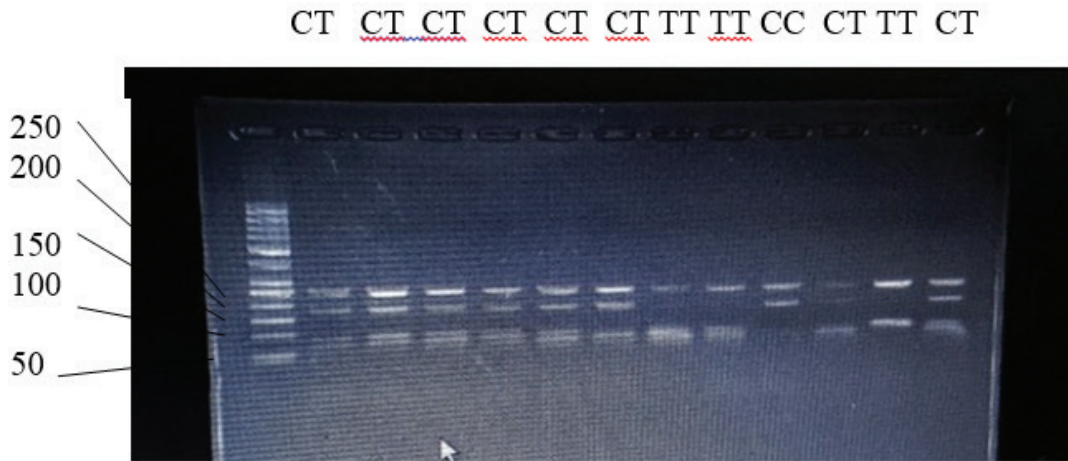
Restriction digestion of PCR products demonstrating the patterns of different genotypes of MYH9 on 2% agarose, 100V; bands of 243+178 bp (CC), 243+92+86 bp (TT) and 243+ 178+92+ 86 bp (CT)
